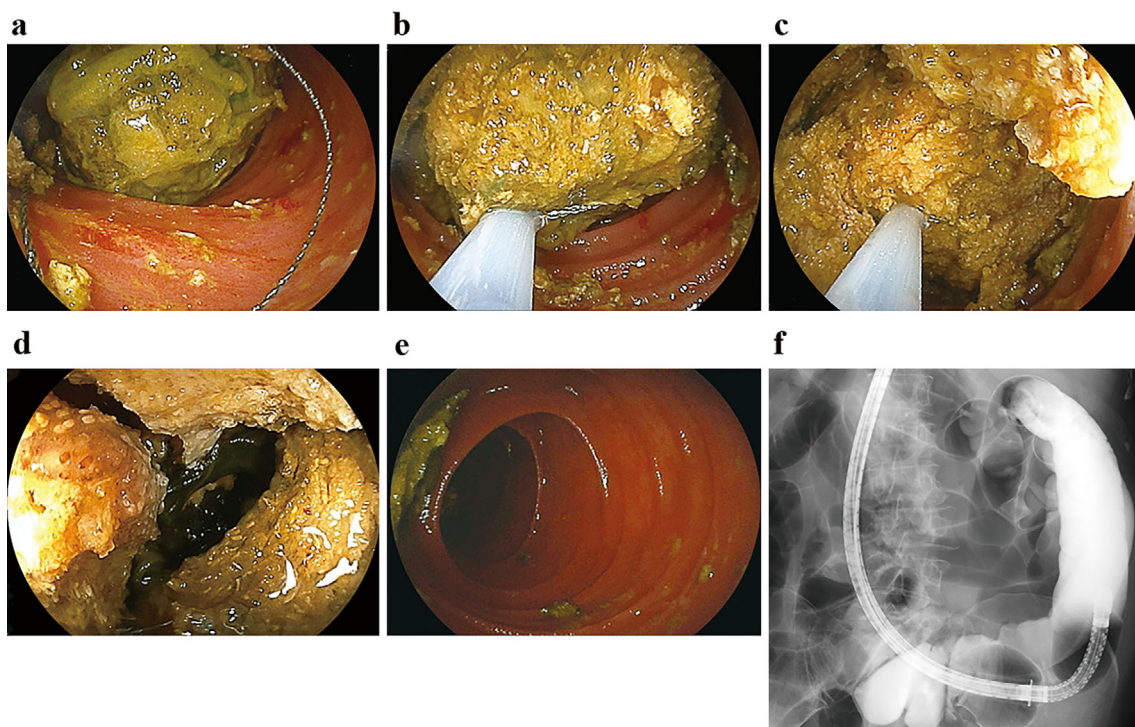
a The foreign body was grasped with a snare (SD-210 U-25; Olympus, Tokyo, Japan), strangulated (b), and strongly pulled directly into the endoscope forceps channel outlet of the endoscope for shredding (c, d). Repeating this procedure multiple times crushed the foreign body, and the endoscope was able to be advanced toward the anus (e). After crushing, the large translucent image disappeared, and good passage through the intestinal tract was confirmed by enteroscopy-guided radiography using gastrografin (f).
